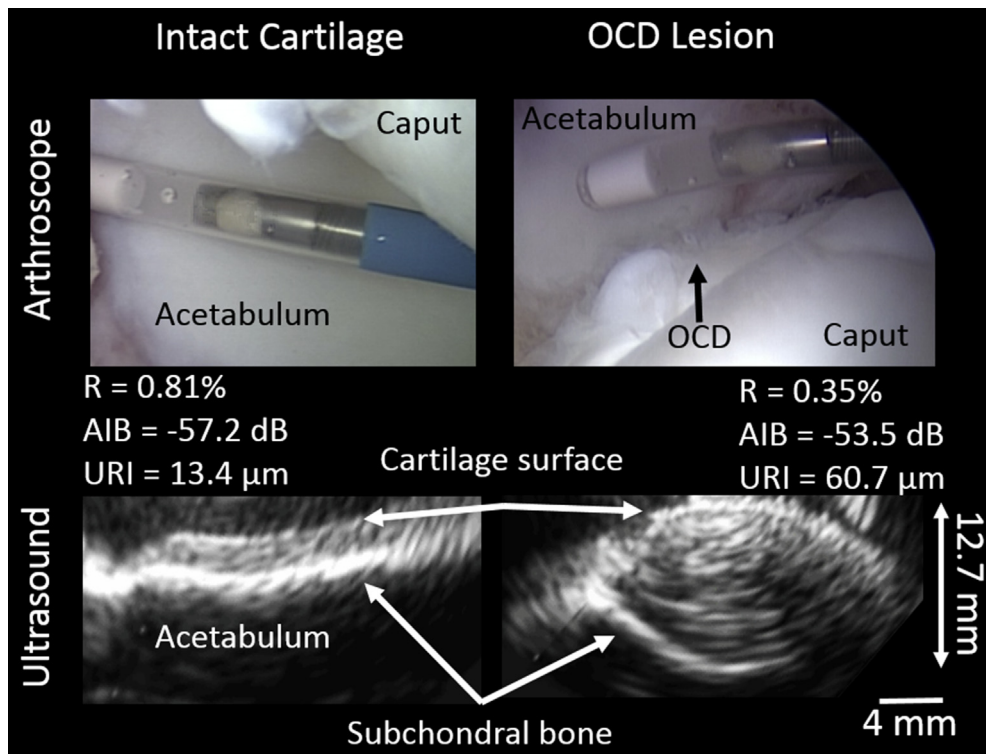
Arthroscopic and ultrasound images of intact cartilage in acetabulum (ultrasound catheter in anterolateral portal) and osteochondritis dissecans (OCD) lesion in femoral caput (ultrasound catheter in anterior portal). The ultrasound catheter and arthroscope were inserted into the hip by use of the anterior and anterolateral portals. Measurement of OCD lesion depth, as well as evaluation of the integrity of the cartilage inner structures and subchondral bone, was possible with the arthroscopic ultrasound technique. Furthermore, the calculation of quantitative parameters reflecting the status of the cartilage layer was possible. The quantitative ultrasound parameters are shown above the ultrasound images. (AIB, apparent integrated backscattering; R, reflection coefficient; URI, ultrasound roughness index.)
